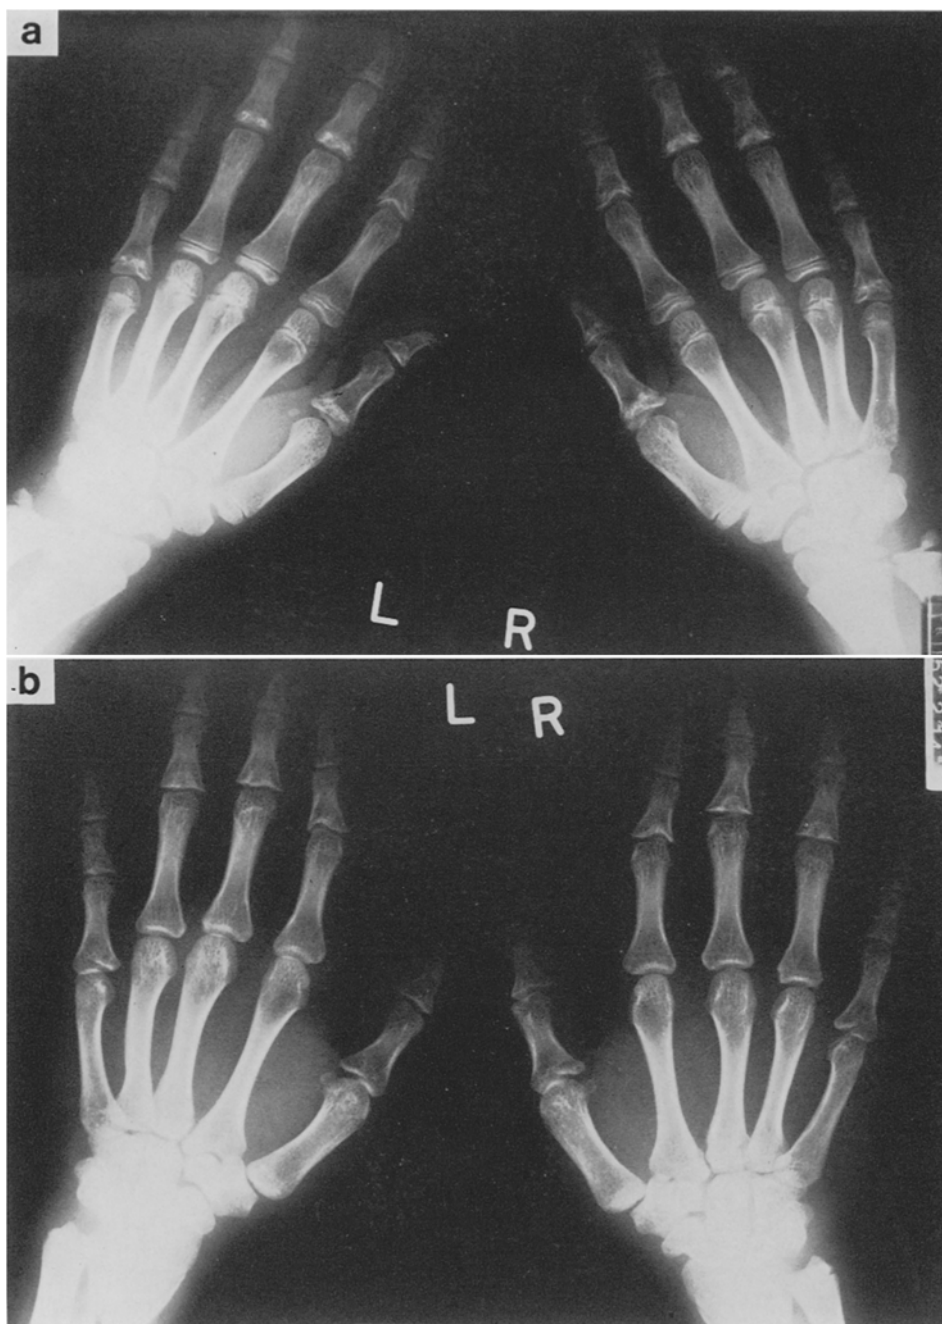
Dorso-palmar roentgenograms of the hands showing type of 12 cone-shaped epiphyses of the middle phalanges of the index through little fingers and of the basal phalanx of the little finger.
